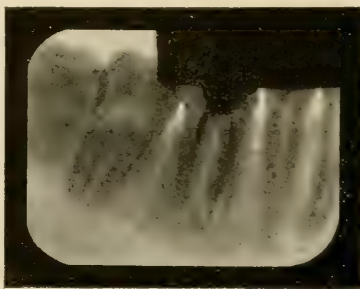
Same case as Fig. 436A, made with X-rays passing through tooth as indicated by arrow No. 3, Fig. 436. The wires in the mesial canals are superimposed throughout most of their length.
